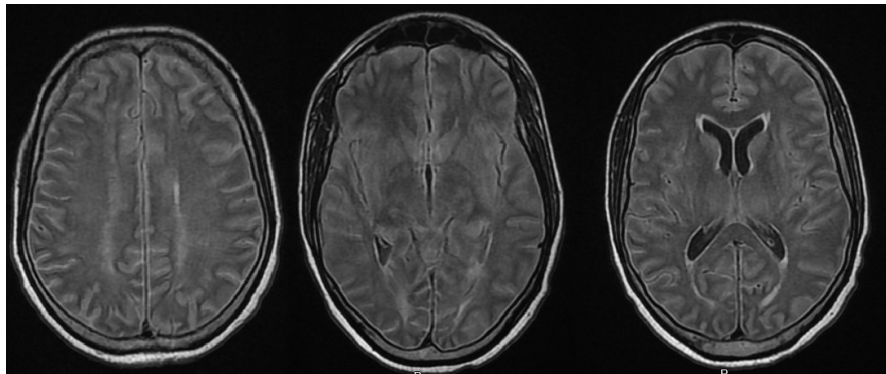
FLAIR sequence, brain MRI showing diffuse brain edema along with high signal changes on the sulci and CSF space with abnormal leptomeningeal signal.
